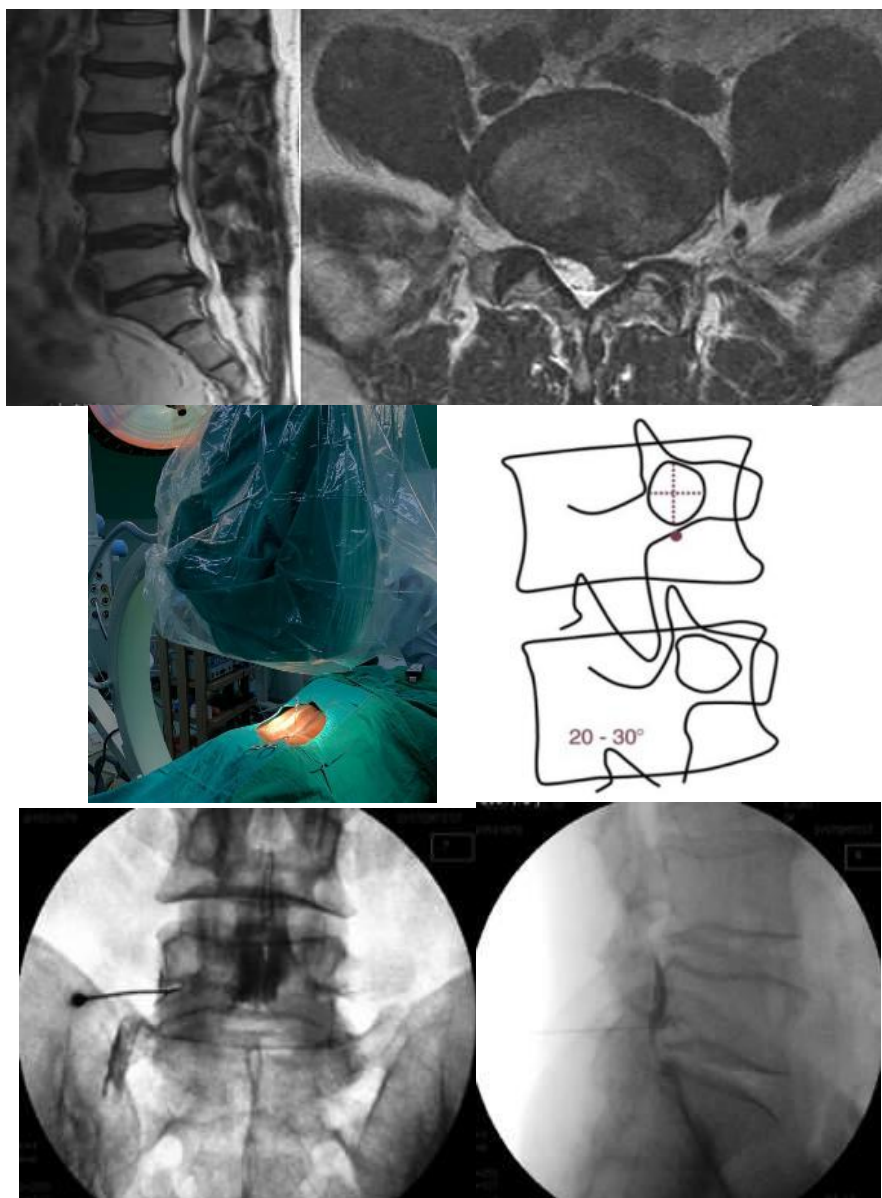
MRI showing PIVD at L5-S1 level. Fig 3 – Patient positioning. Fig 4 – Target point for TFEB. Fig 5,6- spreading of contrast agent .
